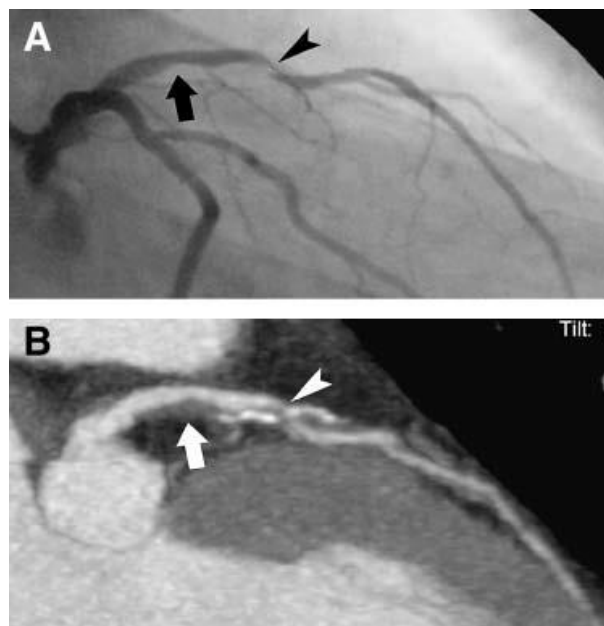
Luminal narrowing in proximal left anterior descending artery (LAD, arrow) and stenosis in middle LAD (arrow head) in a 66 year old male. A) Coronary catheterization X-ray image showing the fine structure of the arterial branches and apparent vessel narrowing. B) Thin-slab maximum intensity projection (MIP) across the LAD plane from a 64-slice multi detector CT scan, showing non-calcified plaque in proximal LAD and mixed calcified and non-calcified atherosclerotic plaque in middle LAD. Reprinted with permission from [7].
